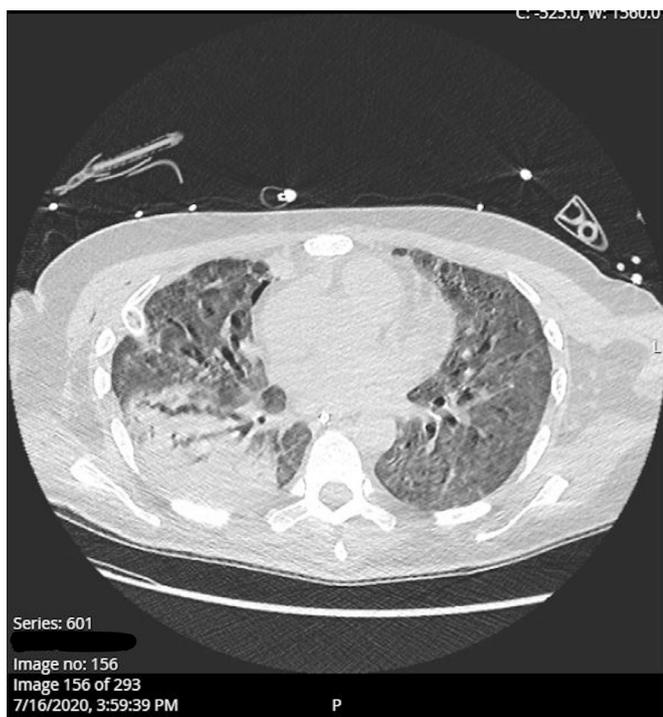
CT scan of the patient's chest showing recurrent acute respiratory distress syndrome and pneumonia, basilar view.
